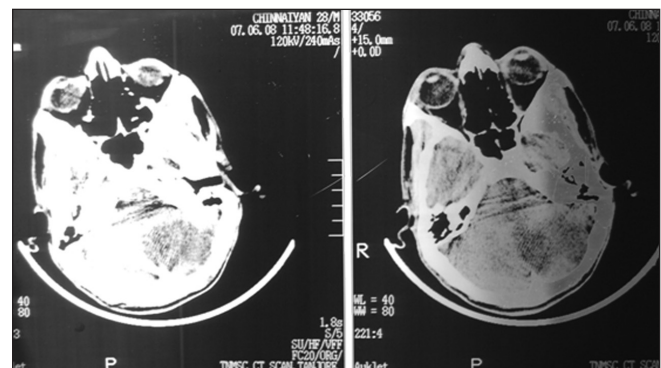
Computed Tomography of brain showing hypo dense lesion in left cerebellar hemisphere suggesting vascular infarct
